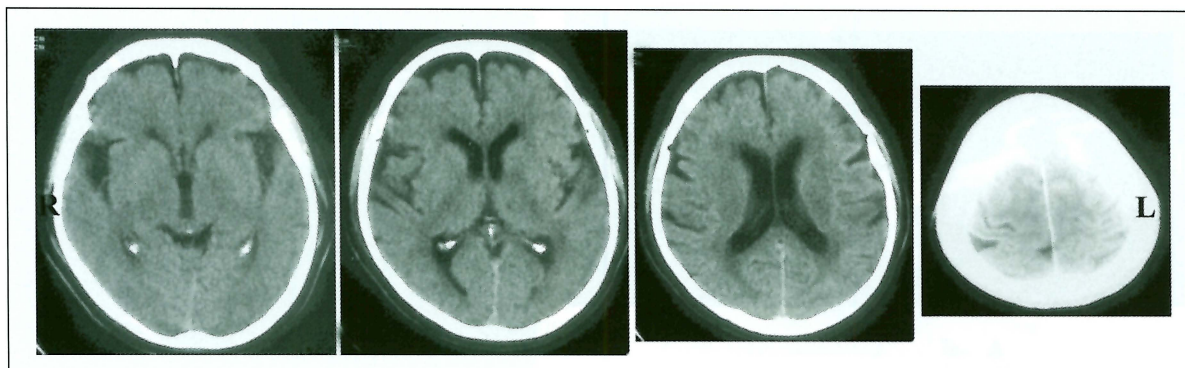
Initial CT image, axial view, showing no early CT signs.
